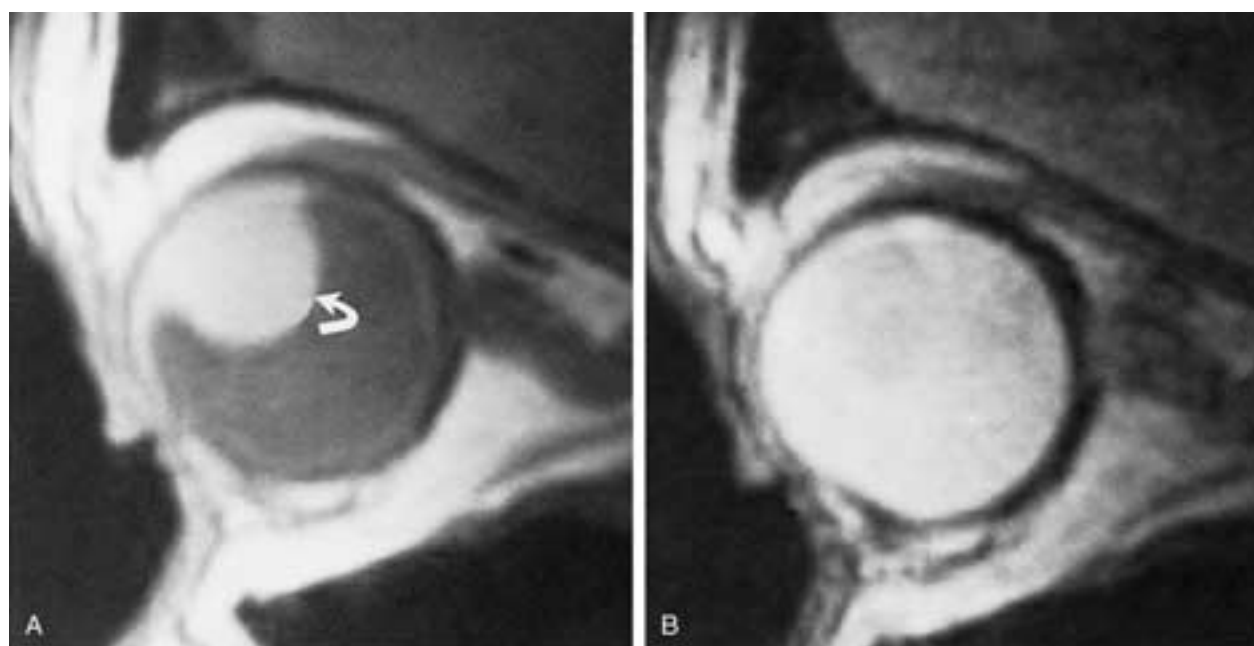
Malignant uveal melanoma. A, Sagittal PW and B, T2-weighted MR images. Scans show a mass (arrow), which is better seen in the PW MR image. The lesion remains slightly hypointense on the T2-weighted MR image.
